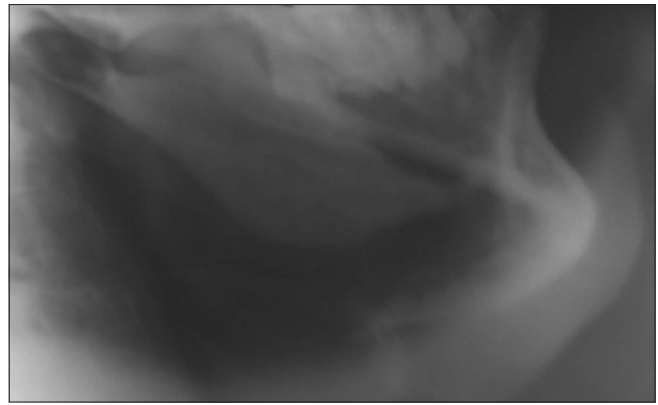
Lateral oblique radiograph of left body of mandible
